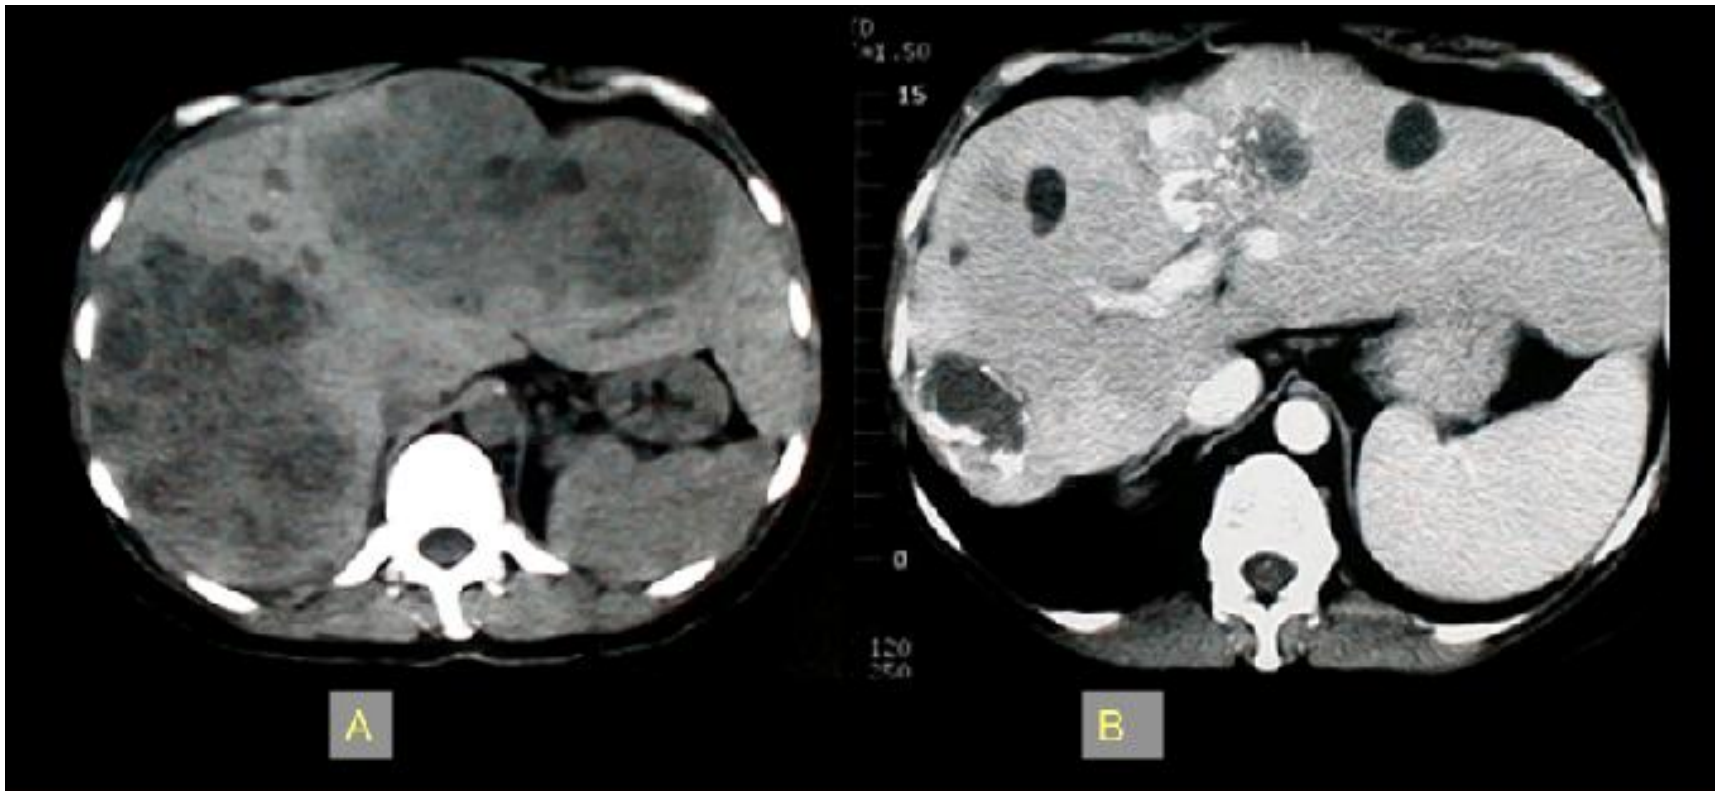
A 56-year-old female patient with symptomatic gastrinoma liver metastasis that progressed despite systemic chemotherapy. She received 4 sessions of conventional transarterial chemoembolization (TACE) that led to complete symptomatic remission and disease control. Computed tomography scan before TACE shows large tumor burden in both lobes (A). Computed tomography scan performed 5 years later shows excellent oncologic result (B).
